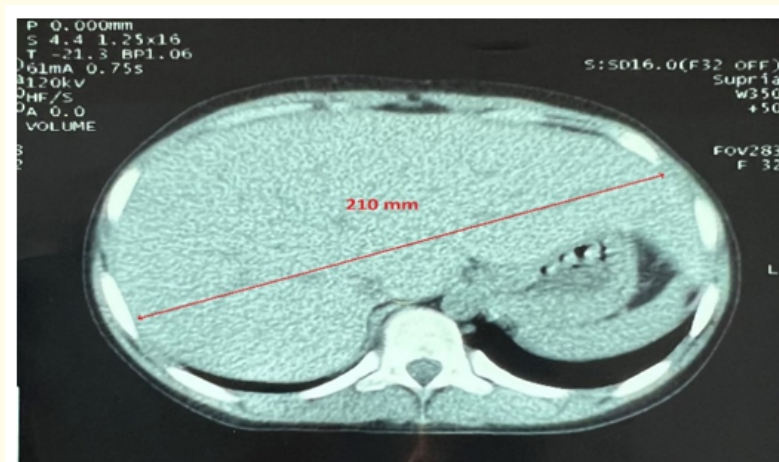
Image of patient's abdominal CT showing a massive hepatomegaly (estimated at 210 mm), with regular contours.
